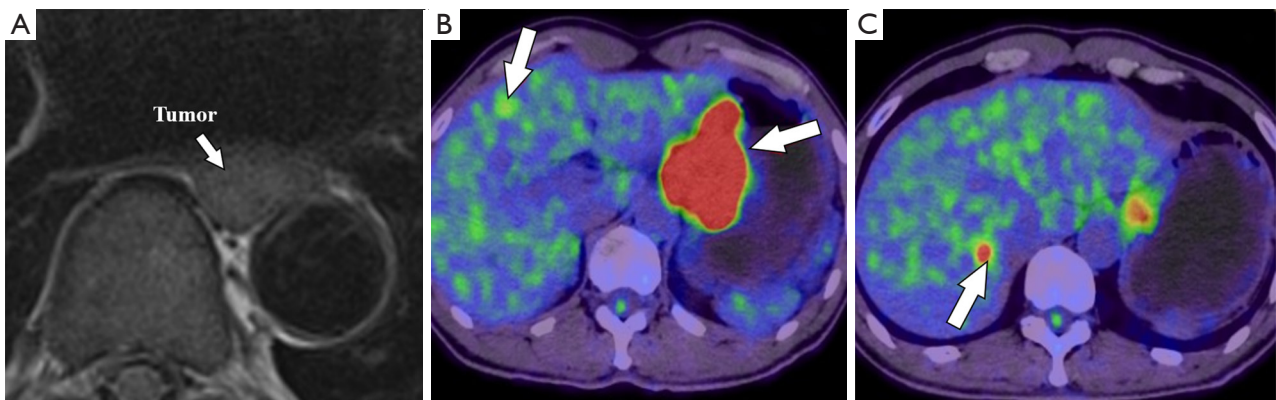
A 62-year-old male esophageal cancer patient with liver metastases: (A) T2WI BLADE and (B,C) PET/CT. The liver metastases exhibit high metabolism (white arrows in B and C). T2WI, T2-weighted imaging; PET/CT, positron emission tomography/computed tomography.
